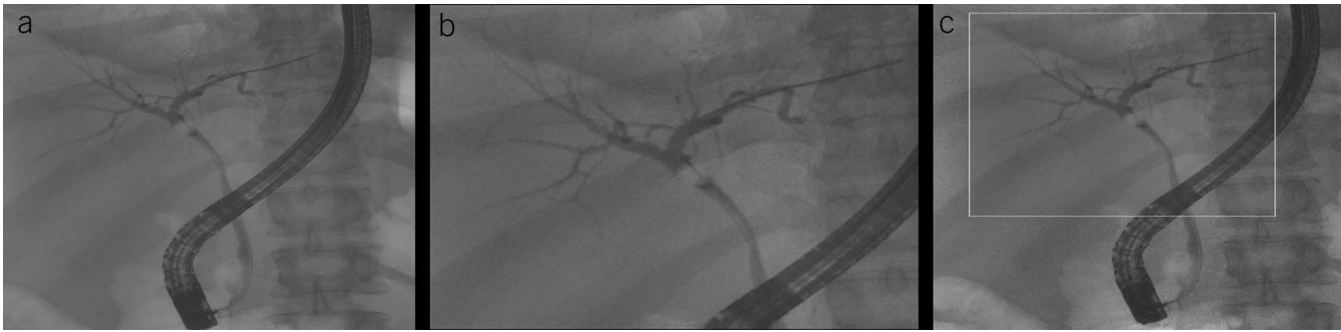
(a) Left image: Depiction of current standard with complete field of view (FOV) on x-ray. (b) Center image: Using artificial intelligence-enabled fluoroscopy technology, to minimize radiation exposure, the gastrointestinal endoscopist could collimate down to just the site of intervention. However, the complete FOV is reduced and contextual image information is lost in the periphery and therefore is impractical for clinical application. (c) Right image: The optimal approach whereby artificial intelligence processes the image data in real-time and controls an ultrafast collimator such that radiation exposure is minimized to the region of interest, such as an area of instrumentation. In high-reduction mode, artificial intelligence-enabled fluoroscopy captures a complete FOV image by opening the collimator at a 1,000 mS interval and then reregisters the full FOV background image with the collimated image and presents the seamlessly combined images, as shown here.
